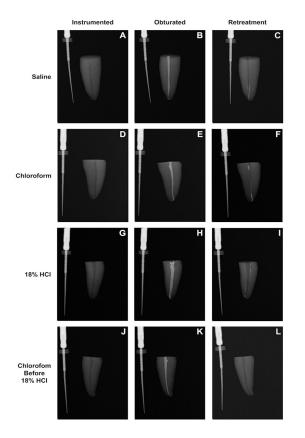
Removal of Sealer using various solvents: Remnant Sealer was observed in radiographs of obturated roots of single rooted teeth using various solvents. Instrumented canals prior to obturation (A, D, G, and J), obturated canals (B, E, H and K), and cleaned canals (C, F, I, L) were examined. Solvents tested were saline (A-C), chloroform (D-F), 18% HCl (G-I) and chloroform followed by 18% HCl (J-L).
